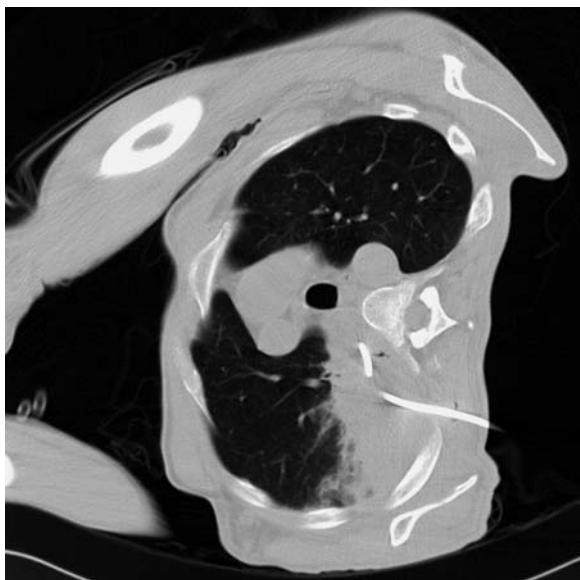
CT-guided percutaneous drainage of a left upper lobe abscess. The drainage is performed with the abscess dependent to minimize the risk of aspiration
